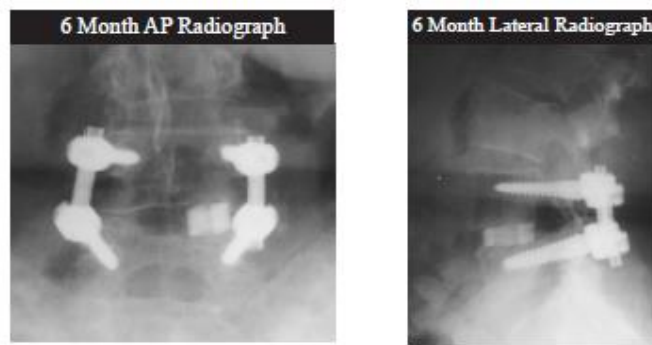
Radiograph imaging of EJ
